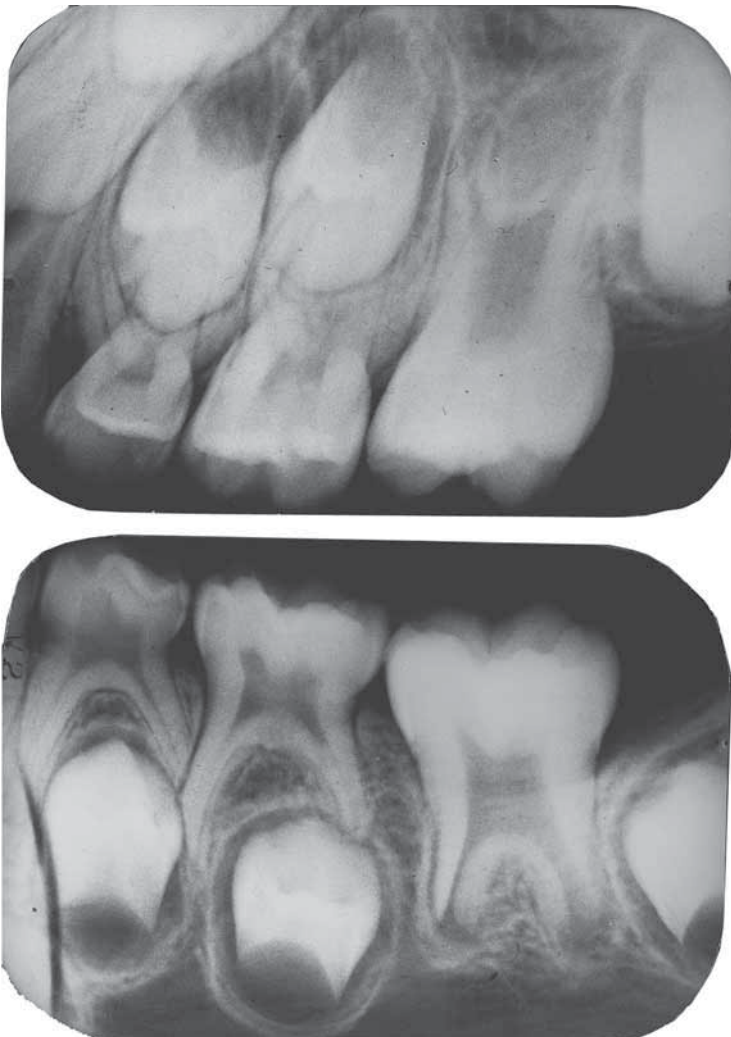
Learning Case 2: Based on these radiographs of mixed dentition, estimate the dental age of this child. (Radiographs courtesy of Professor Donald Bowers, Ohio State University.)
